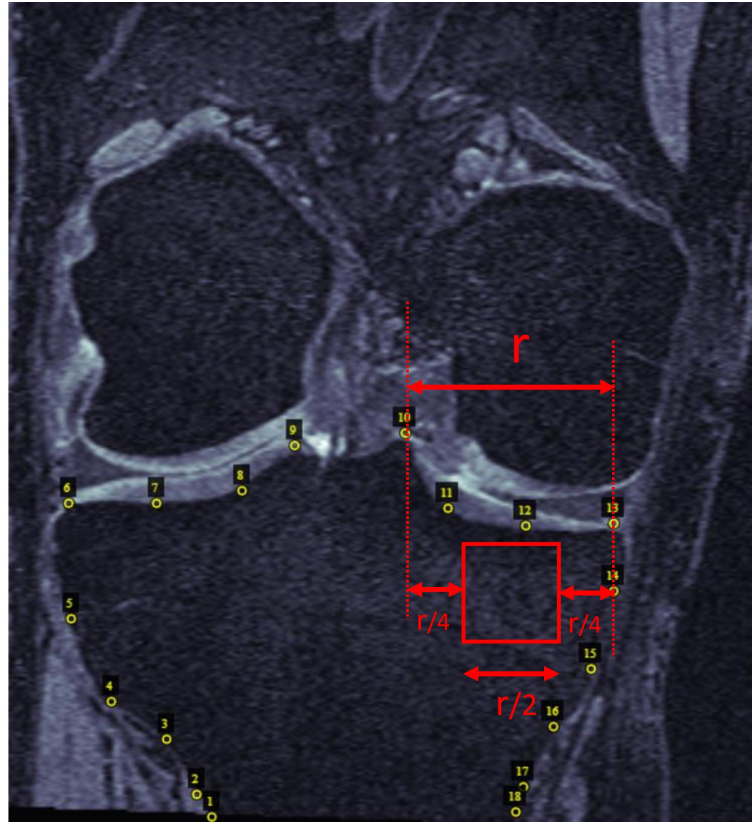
Region of interest (ROI) used for MR images. The size of ROI is proportional to the size of the bone (the width between margin of tibia point and the centre of the medial condyle)
